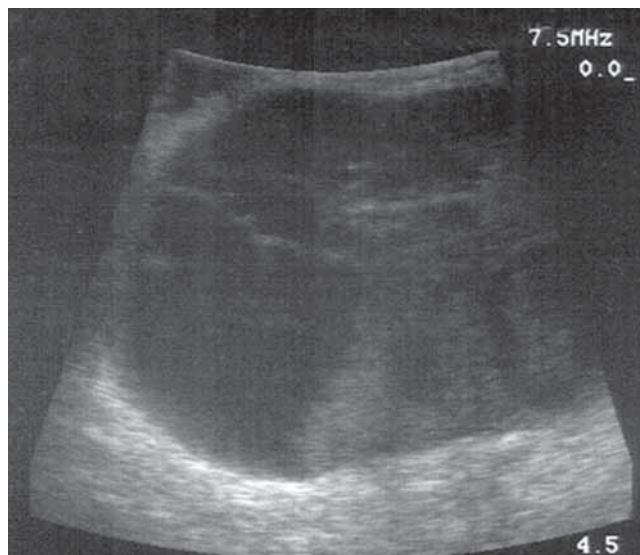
If the left adrenal proves difficult to find, laparoscopic ultrasonography may be employed to locate the gland and the lesion within the retroperitoneal fat. This laparoscopic ultrasonogram shows an enlarged left adrenal gland secondary to metastatic squamous cell carcinoma of the lung.
